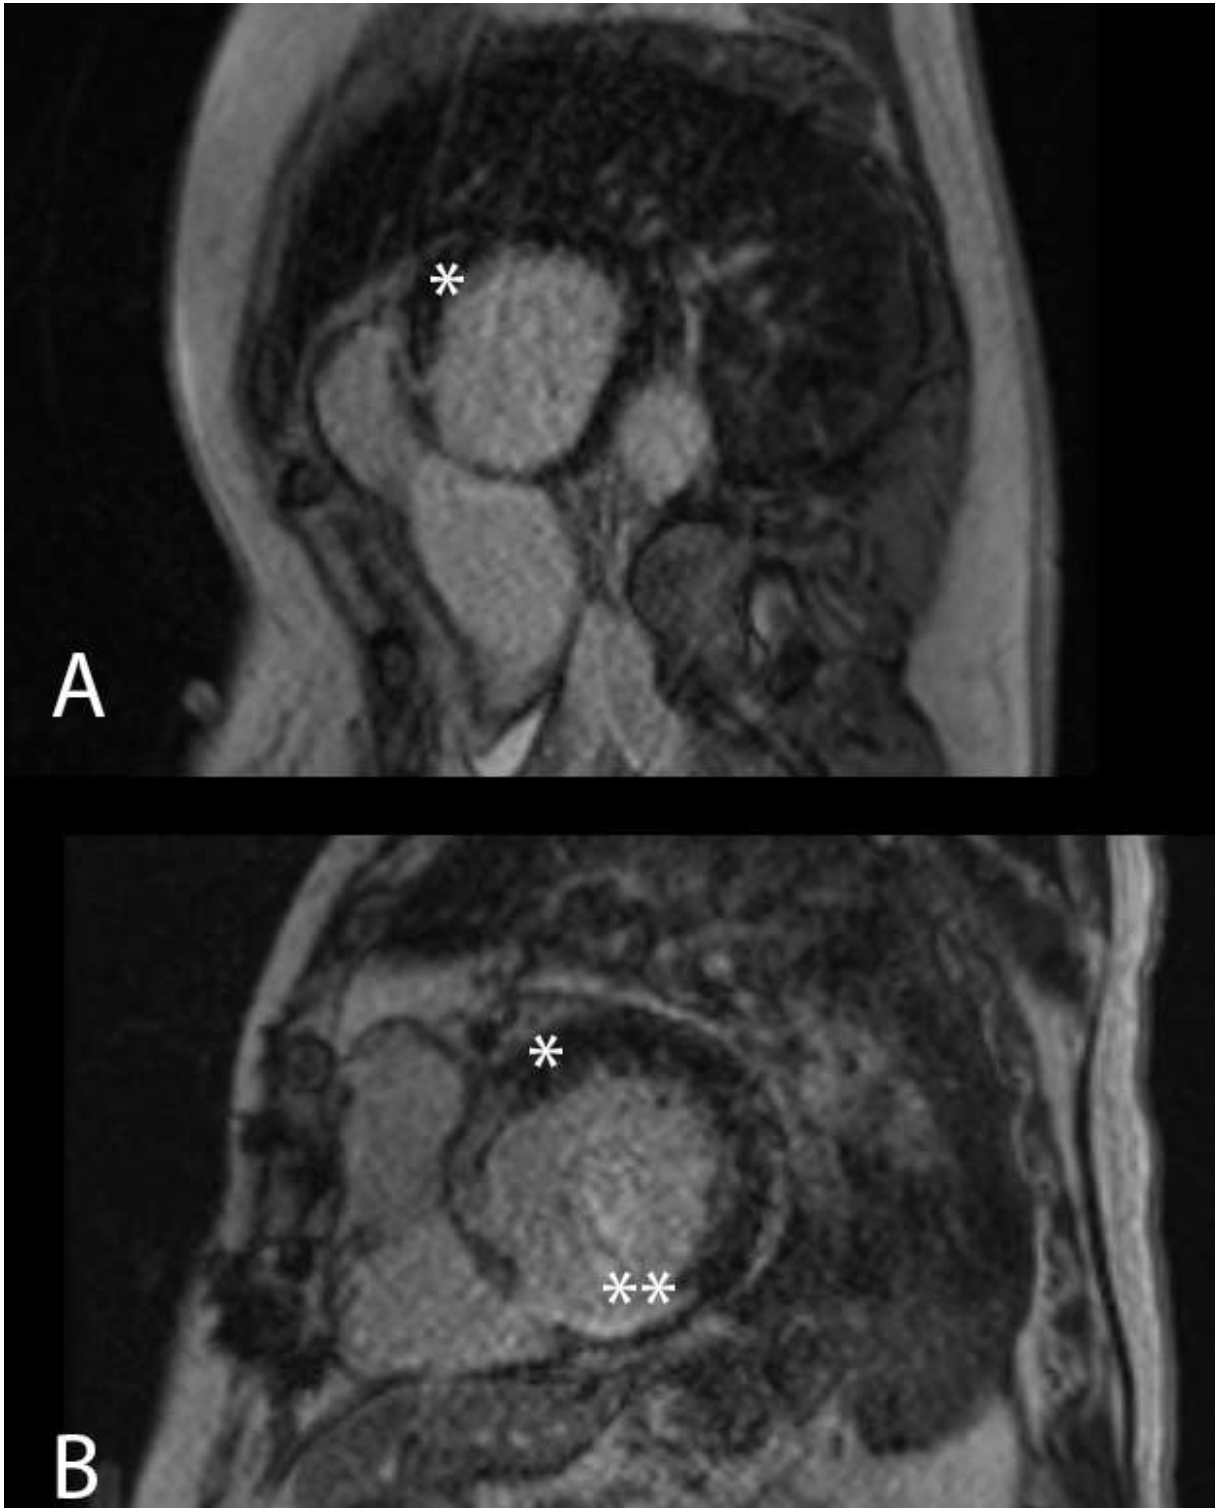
Cardiac magnetic resonance imaging in patients after ethanol ablation. A. The first case showed a minimal gadolinium enhancement in the basal anterior septum marked by asterix (*). B. The second case demonstrates two discrete areas of late gadolinium enhancement. The first area, marked by a single asterix (*) is gadolinium enhancement in the basal anteroseptum. The second area, marked by a double asterix () is the transmural gadolinium enhancement in the inferior wall due to previous myocardial infarction and scar homogenization with radiofrequency ablation.
